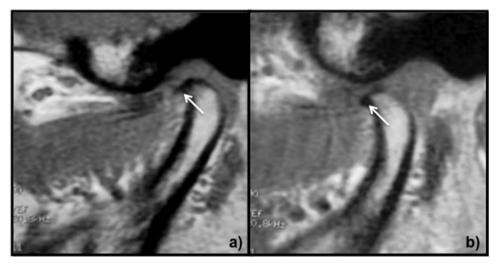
T1-weighted sagittal view: (a) mouth closed; (b) mouth open. Angled exophytic bone tissue formation in the mandibular condyle (arrows), indicating the presence of osteophytes (morphological change).
